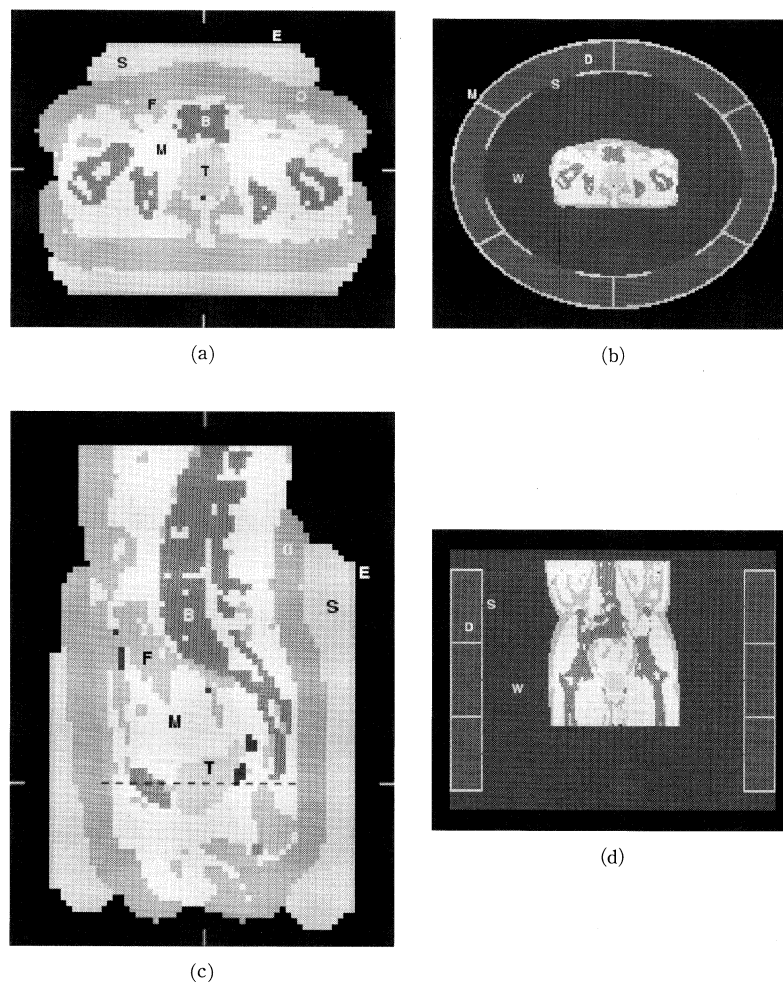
Patient model (a, c) in RF8 applicator and (b, d) in cavity slot applicator. The CT data set is segmented in muscle (M), fat (F), bone (B) and tumour (T) tissue, (a, b) transversal, (c) sagittal and (d) coronal slice centrally through the tumour. The RF8 applicator is modeled with circular electrodes (E) coupled to the patient with saline bolus bags (S) and overlay boli (O). The cavity slot applicator (b, d) is constructed from metal sheets (M), farming cavities filled with deionised water (D) with radiating slots (S). The space between the applicator and the patient is filled with tapwater (W).
